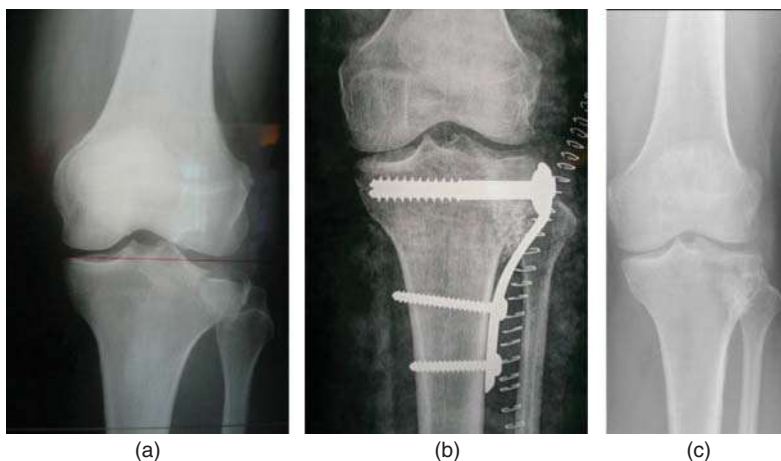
X-ray images of a lateral tibial plateau fracture: (a) before the treatment with granules of S53P4; (b) postoperative; and (c) after 11 years. Source: Pernaa et al. [43]/with permission from Begell House, Inc.
